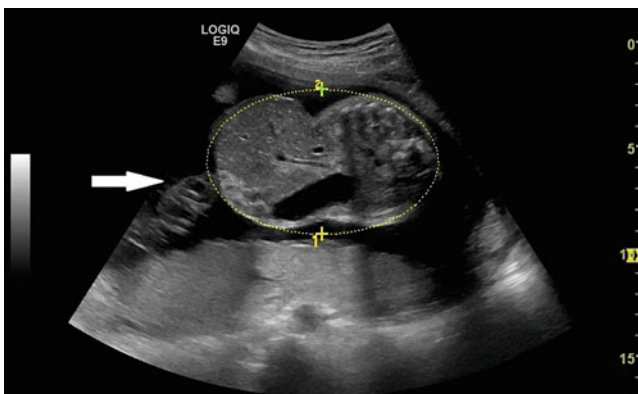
Prenatal ultrasound showing an axial view of the fetal abdomen with a large, liver-containing omphalocele at 29 weeks gestation. The arrow indicates the umbilical cord inserting onto the sac
